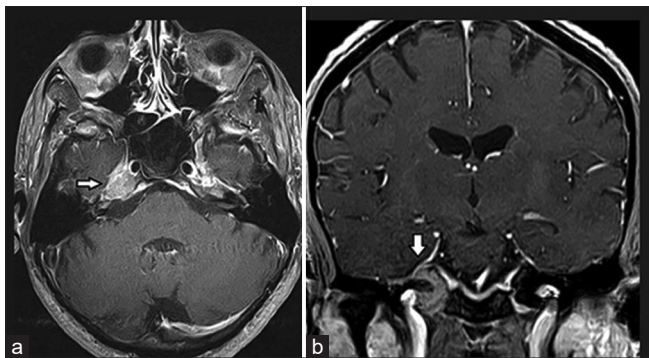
Post-contrast T1-axial (a) and coronal (b) magnetic resonance images. The enhancing lesion was bulging into the premedullary cistern on the right side (arrows). Posteriorly, it was abutting the hypoglossal canal, vestibulocochlear, and facial nerves.
